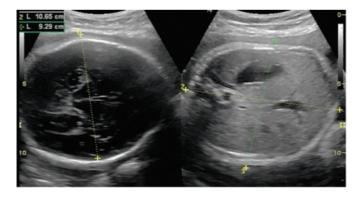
Obstetric ultrasound showing a normal fetus. Source: Clínica Fértile
